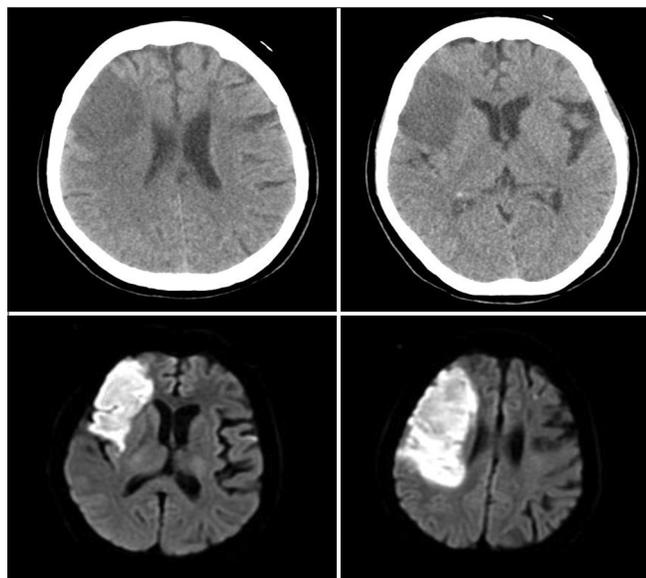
Non-contrast computed tomography (NCCT) and magnetic resonance imaging-diffusion-weighted imaging (DWI) brain image shows different ASPECT score in same patient with hypodensity in NCCT with involvement of M1 and M4 area only, while in DWI it shows restriction in M1, M2, M4, and M5 area as per ASPECT distribution in middle cerebral artery distribution in a patient of hemiparesis
